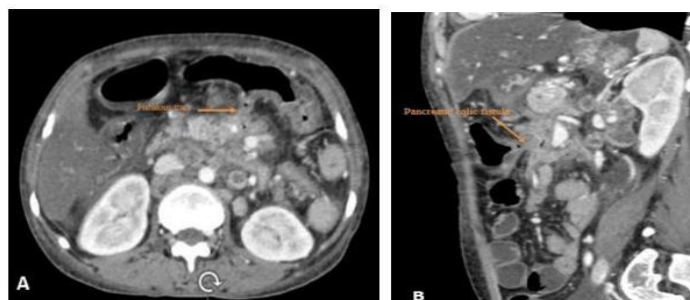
Contrast-enhanced CT images (A – axial, B – sagittal) showing a linear fistulous tract containing air foci extending from the pancreatic bed to the posterior wall of the transverse colon (arrows), consistent with pancreatico-colonic fistula, with associated peripancreatic inflammatory changes.
